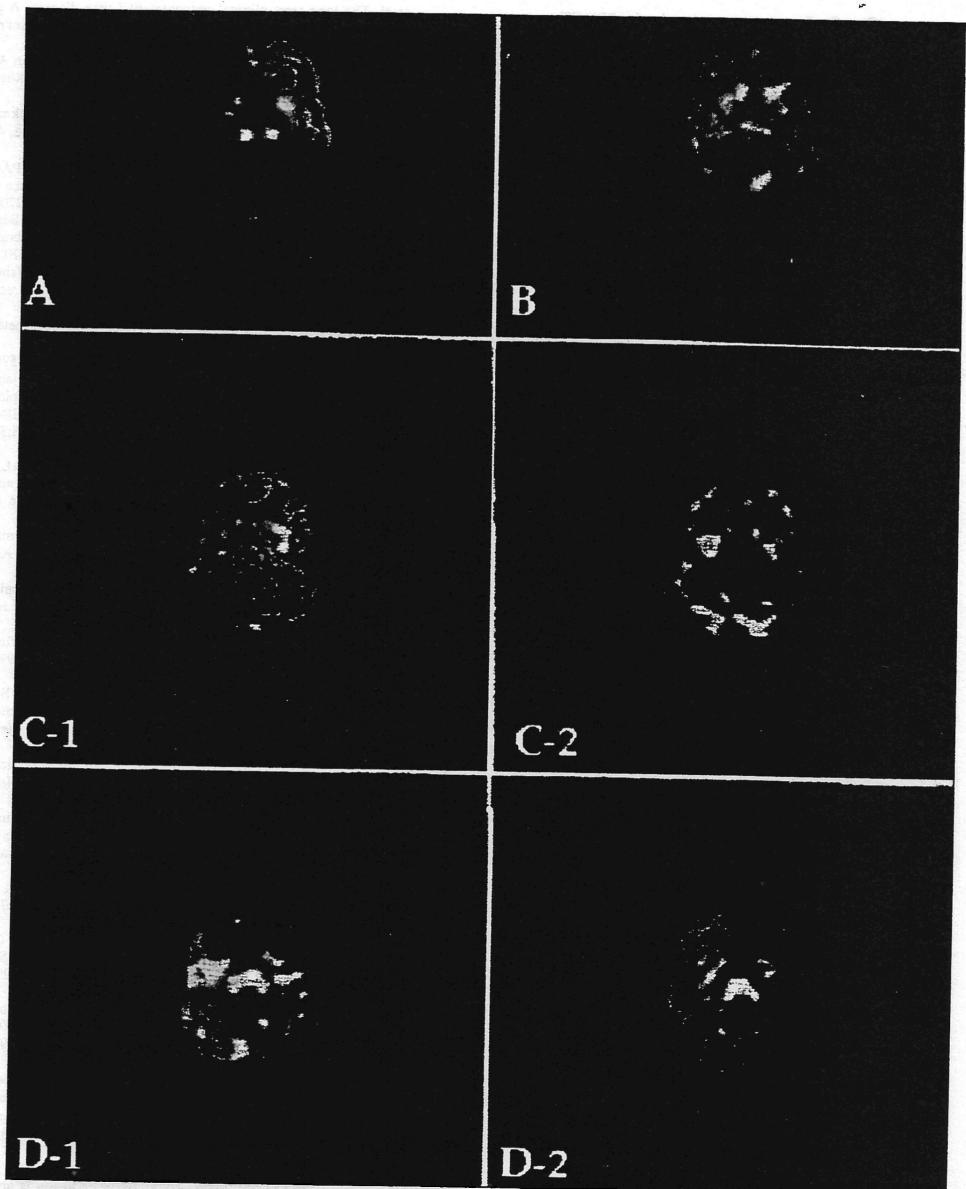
Representative examples of SPECT studies used in the blind read. (A) Alzheimer's disease; (B) cerebral vasculitis; (C-1) baseline—Lyme disease patient; (C-2) same patient after treatment showing improvement; (D-1) baseline—Lyme disease patient; and (D-2) same patient after treatment whose condition worsened.
